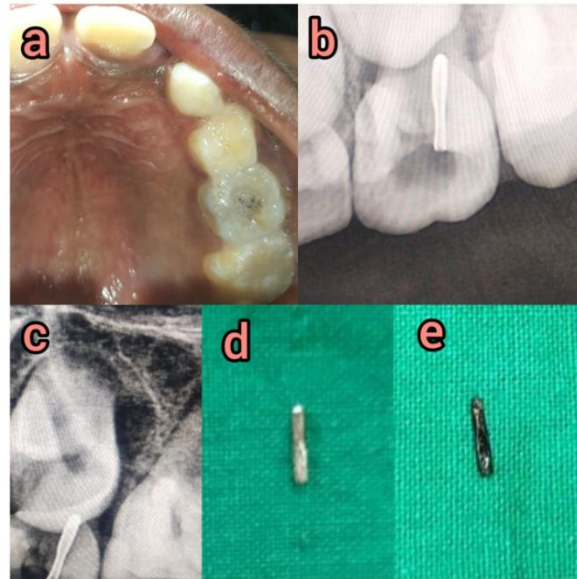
(Case 2) a: Intra oral pre operative photograph i.r.t 65 with food debris, b,c: Radiographs showing lodged foreign object i.r.t 65 damaging the tooth bud of 25, d: pen nib, e: graphite pencil nib retrieved during treatment
